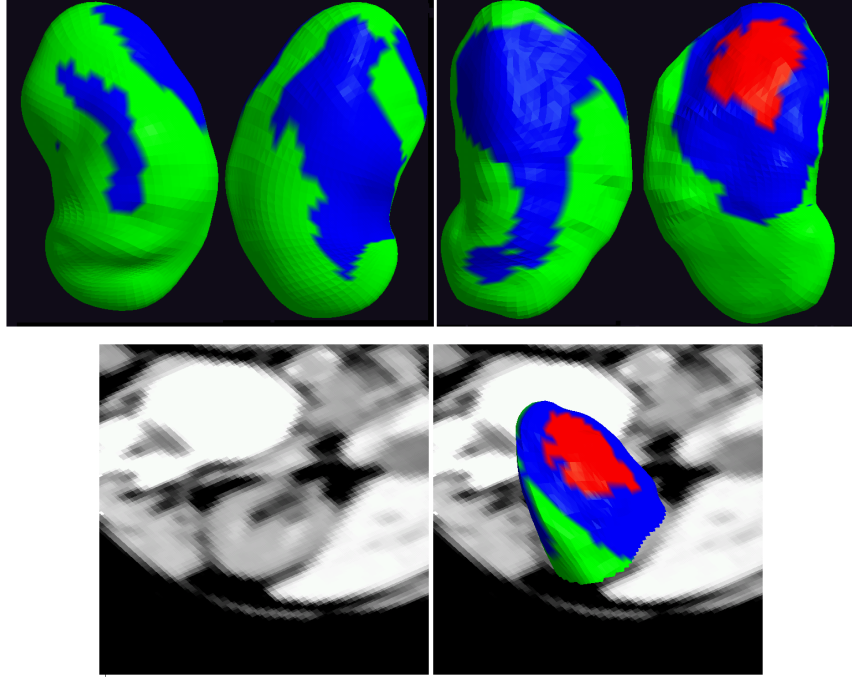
Top: kidneys colored according to the profile type selected at each point, using the same color scheme as before (see Figure 3.4). Bottom: the colored kidney model in situ in an axial CT slice. Note the grey-to-light type where the liver often abuts.
